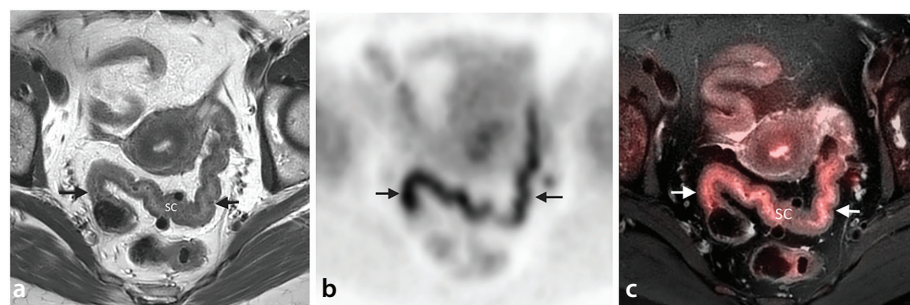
Physiological colonic uptake. The axial T2-weighted image of the pelvis (a) reveals a normal sigmoid colon (SC) (arrows) with incidental diverticula. The axial positron emission tomography (PET) (b) and fused PET/magnetic resonance (c) images show mild physiological fluorodeoxyglucose uptake exhibiting the diffuse and linear pattern in a normal SC (arrows).
